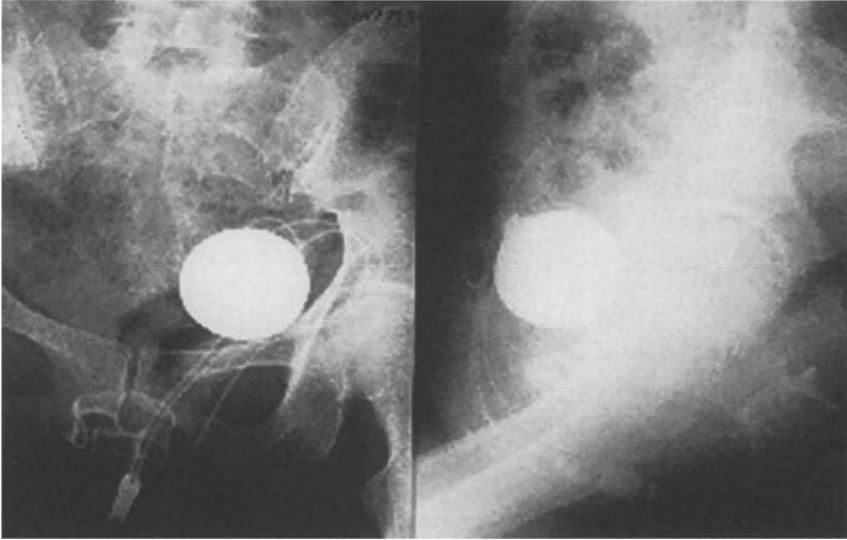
Pelvis X-Ray with the anal cuff deflated
